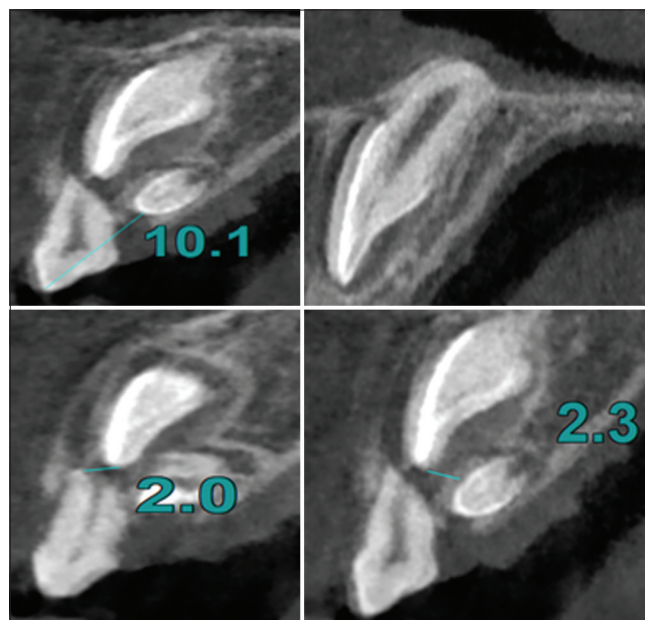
Sagittal section of cone-beam computed tomography
